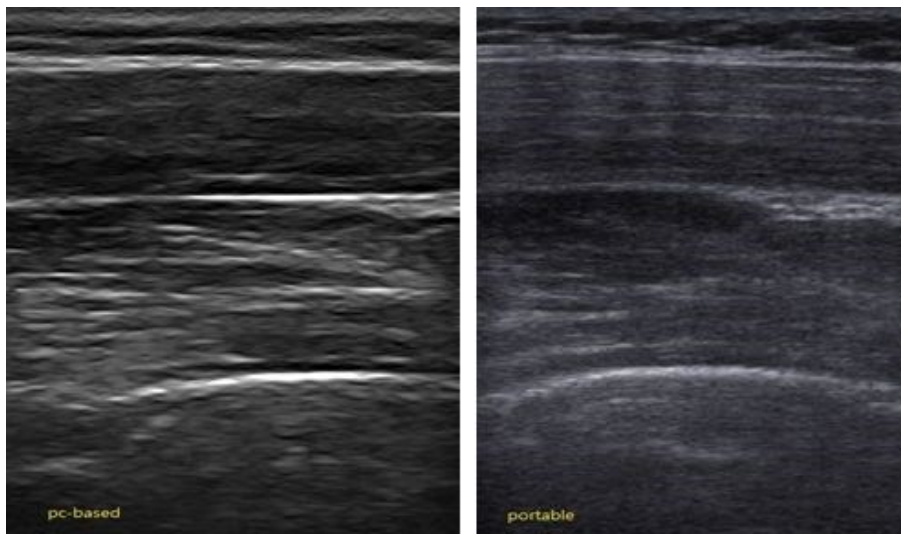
Resolution the difference between the two devices. (A) Personal computer-based muscle viewer. (B) portable ultrasound.
